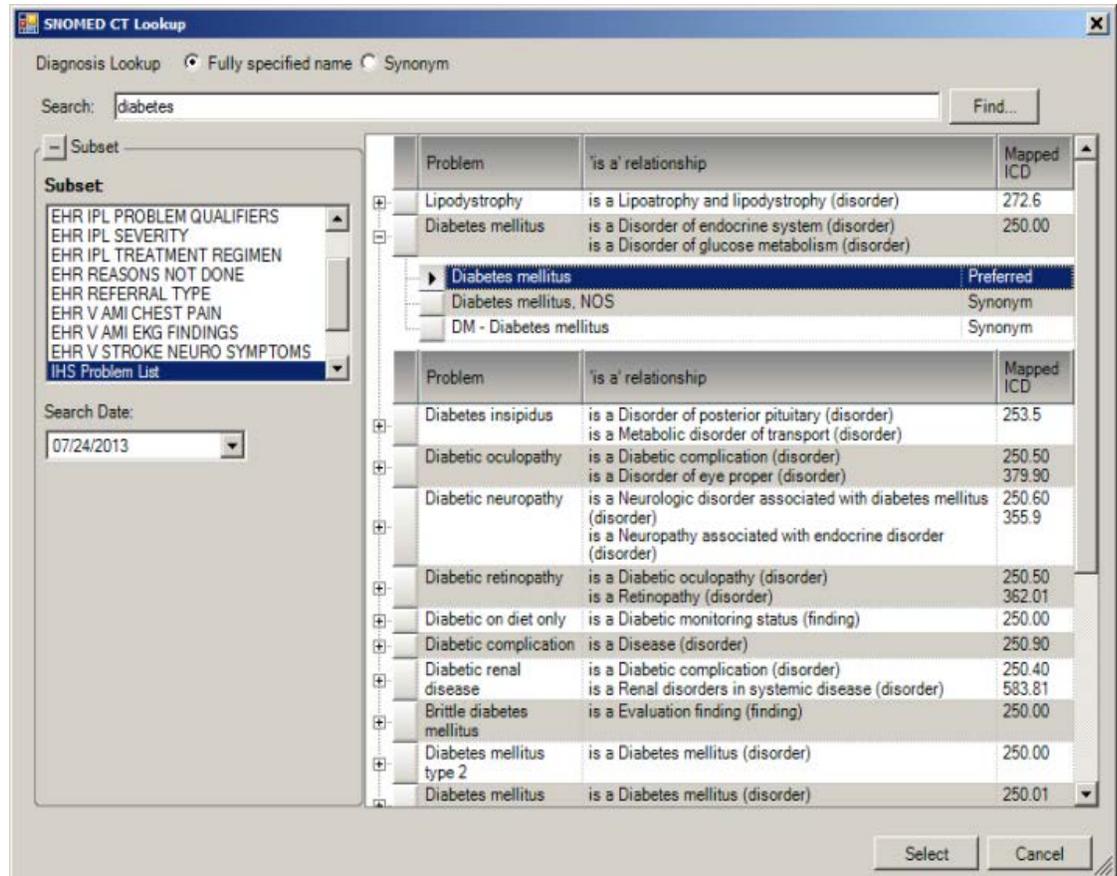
SNOMED CT Lookup dialog
